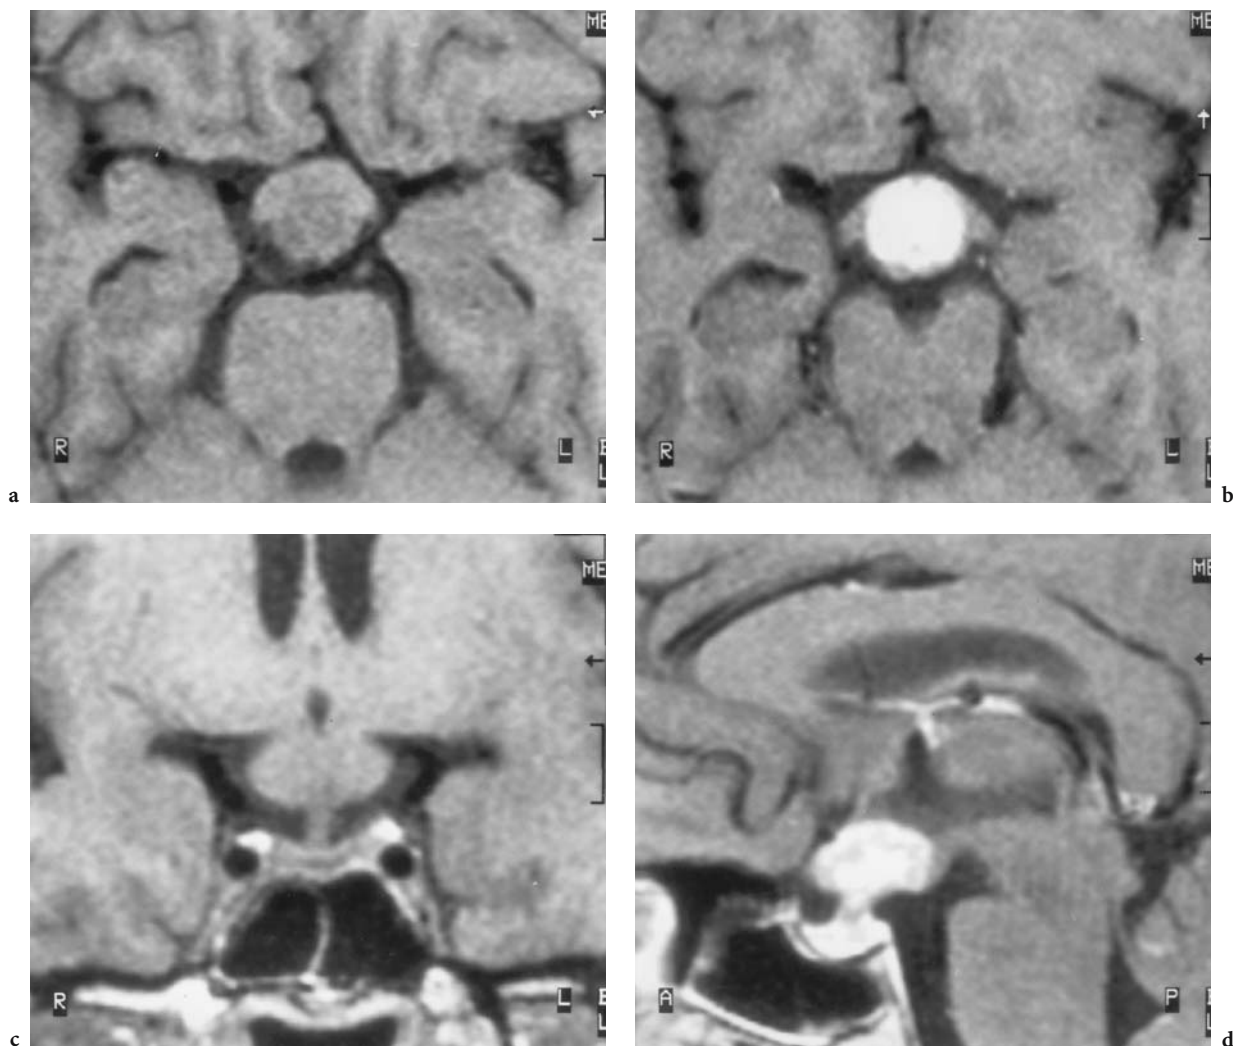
A 38-year-old woman with chiasm syndrome, diabetes insipidus, and a history of breast carcinoma. Diagnosis: hypothalamic and chiasmal metastasis of breast carcinoma. T1-weighted MRI: a Axial native view showing a slightly hypointense lesion dorsal to the chiasm with apparent invasion. b Corresponding contrast-enhanced view, identifying invasion of the chiasm and the proximal optic tracts. c Coronal native view. d Midsagittal contrast-enhanced view, demonstrating metastatic spread throughout the hypothalamus and pituitary stalk (d with permission of MÜLLER-FORELL 2001)
